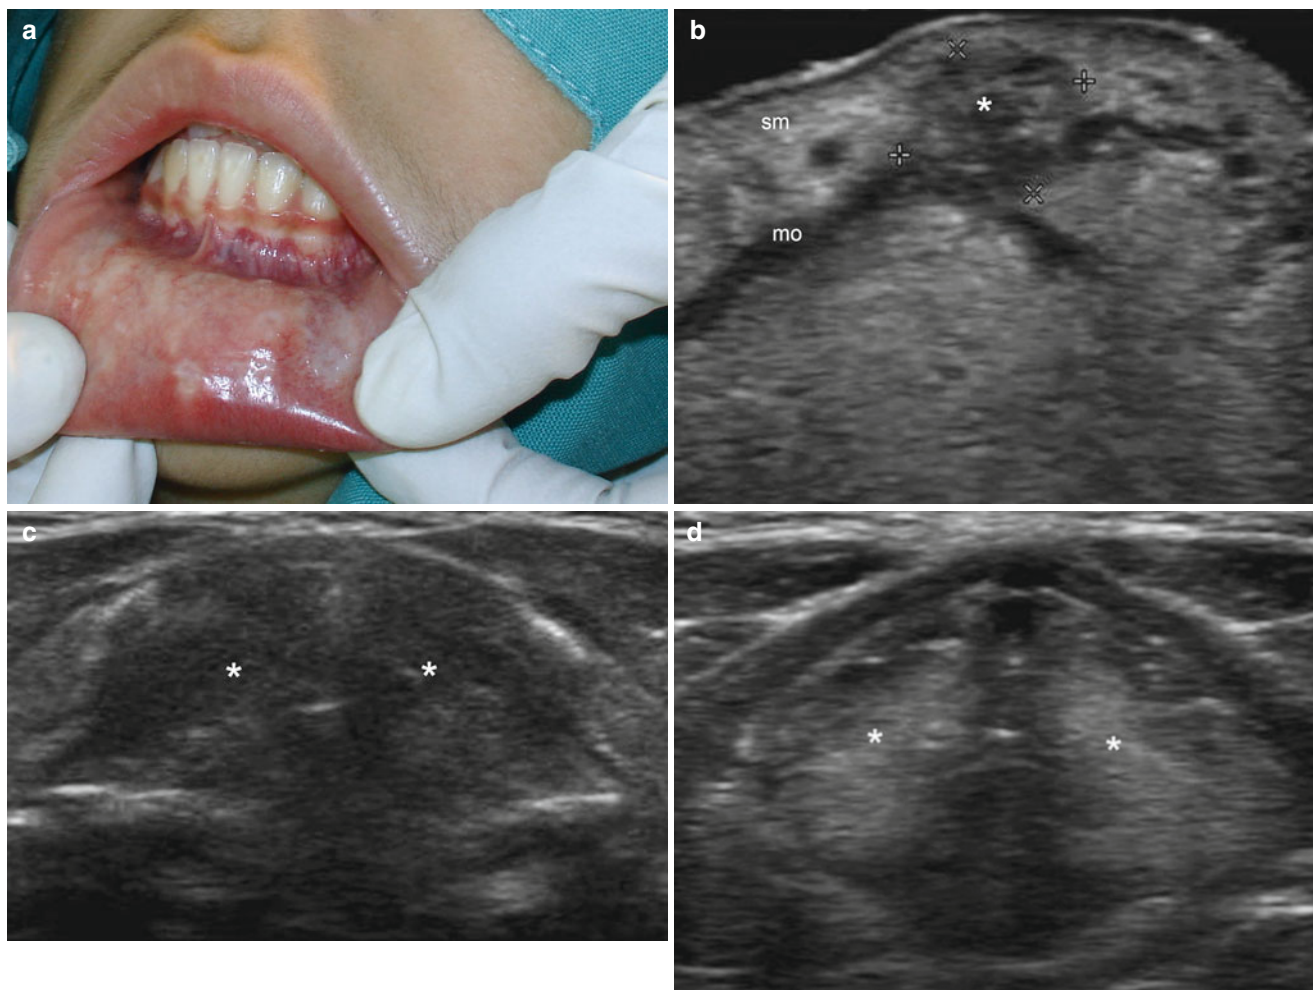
(a–d) Lipoid proteinosis. (a) Clinical white papules in the mucosa of the lip. (b) Ultrasound image (gray scale, transverse view) shows a submucosal hypoechoic deposit (*, between markers) in the lower lip superficially located to the orbicularis oris muscle. (c) Ultrasound image (gray scale, transverse view) shows the normal
